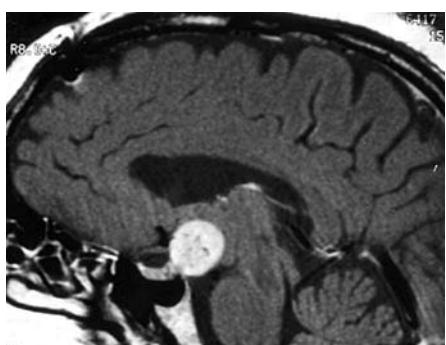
Pituicytoma showing solid, circumscribed growth and diffuse contrast-enhancement on T1-weighted MRI.
